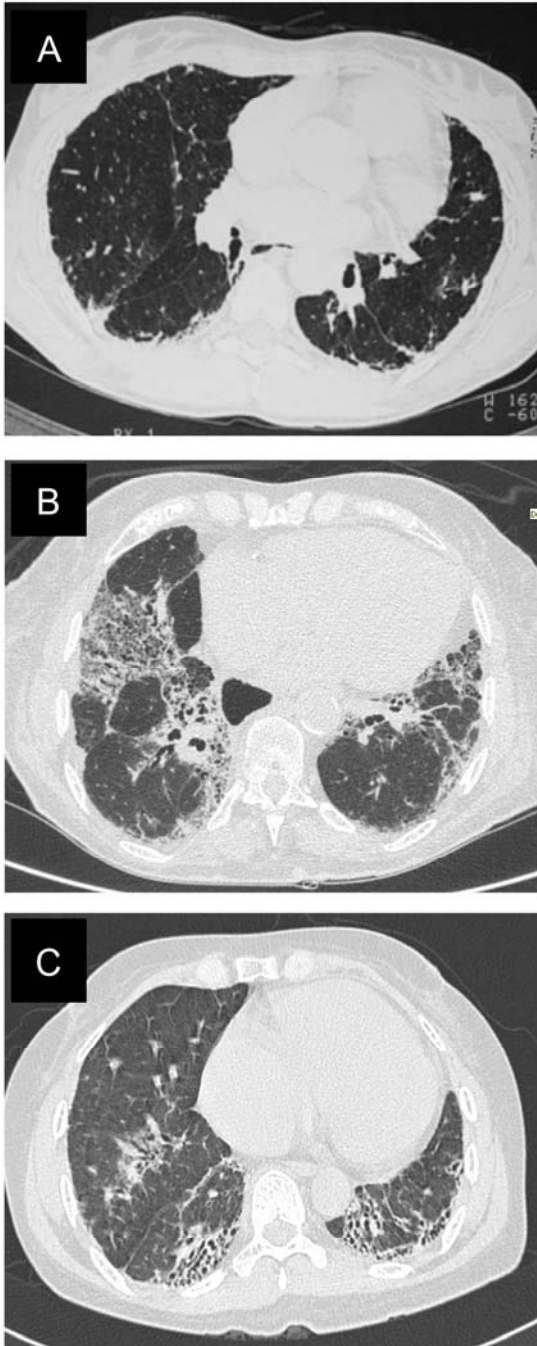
Representative thoracic-CT images of the ILD in patients with severe PH-ILD
